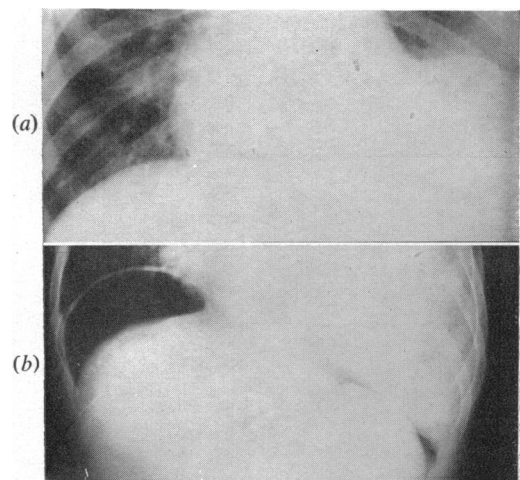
Pleural effusion mimicking high left diaphragm. (a) Plain x-ray film. (b) Film after pneumoperitoneum showing diaphragm to be low.
